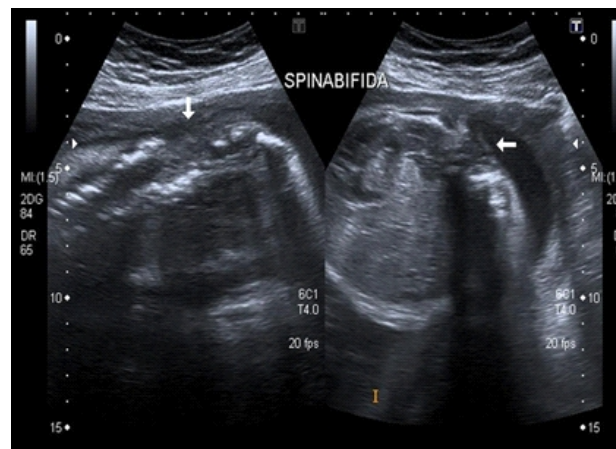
Ultrasound images of fetal spine shows spina bifida at 29 weeks of gestation
